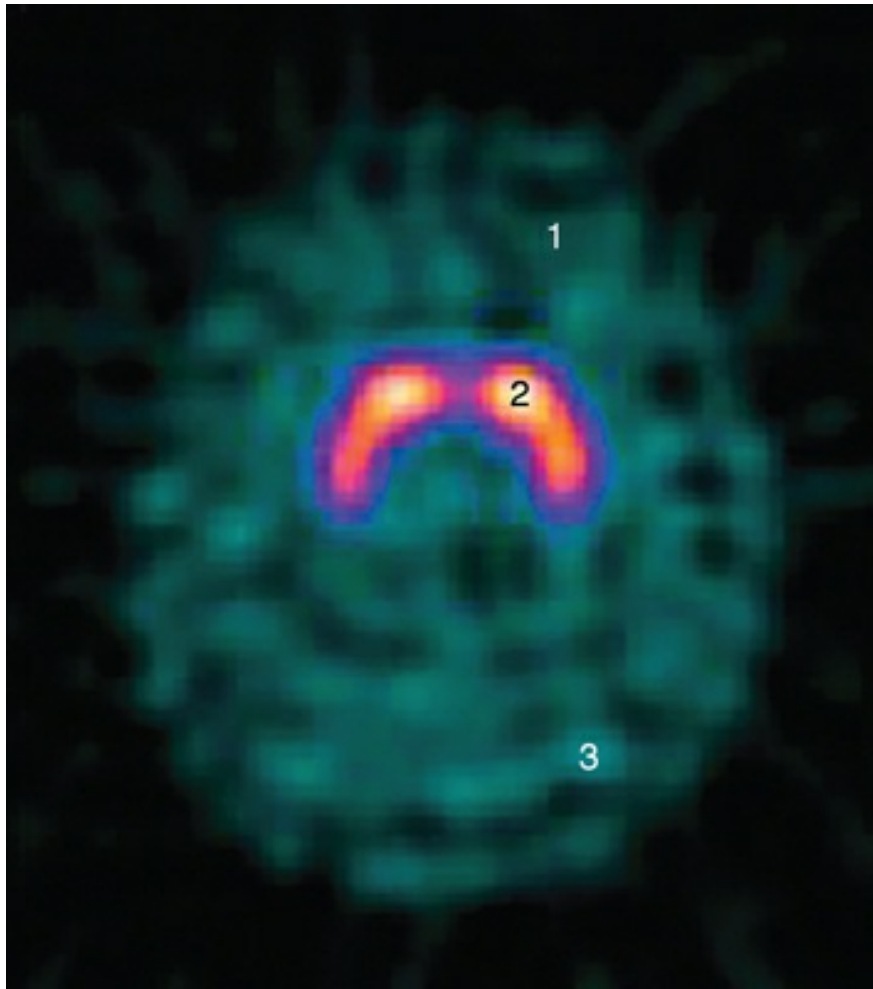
■ A single photon emission computed tomography (SPECT).
